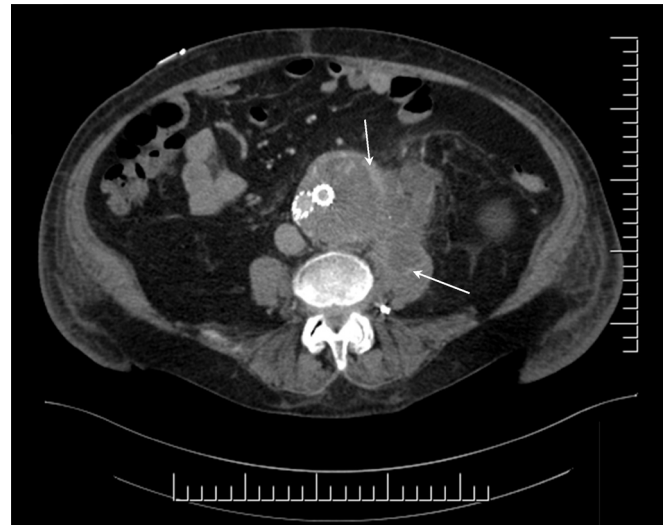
Aortic endograft infection on contrast-enhanced computed tomography (CT) scan demonstrated by rim-enhancing collection, psoas abscess, and locules of gas within the sac.
